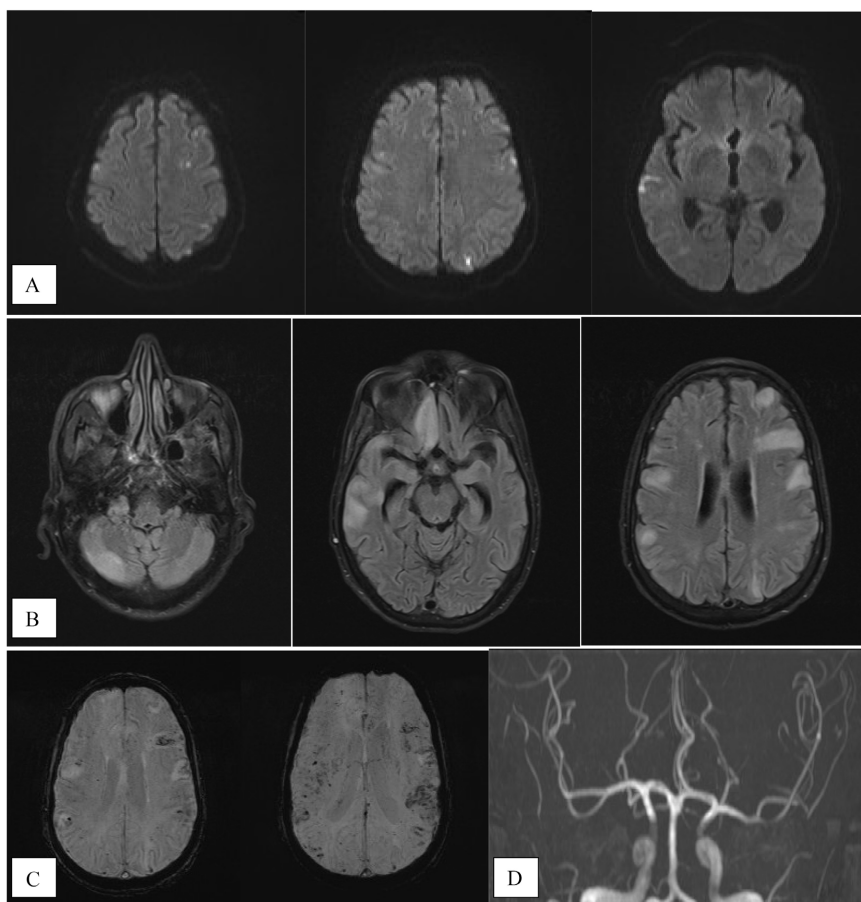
A: Axial slices from the Diffusion sequence. B: Axial slices from the FLAIR sequence. C: SWI sequence. D: 3D TOF sequence. These sequences show multiple cortico-subcortical areas affecting both the posterior fossa and the supratentorial level, appearing on FLAIR with punctate diffusion restriction in some areas, without ADC drop. Presence of cortico-subcortical microbleeds, visible in the SWI sequence. The 3D TOF Angio-MRI sequence does not show any abnormalities in the Circle of Willis.
